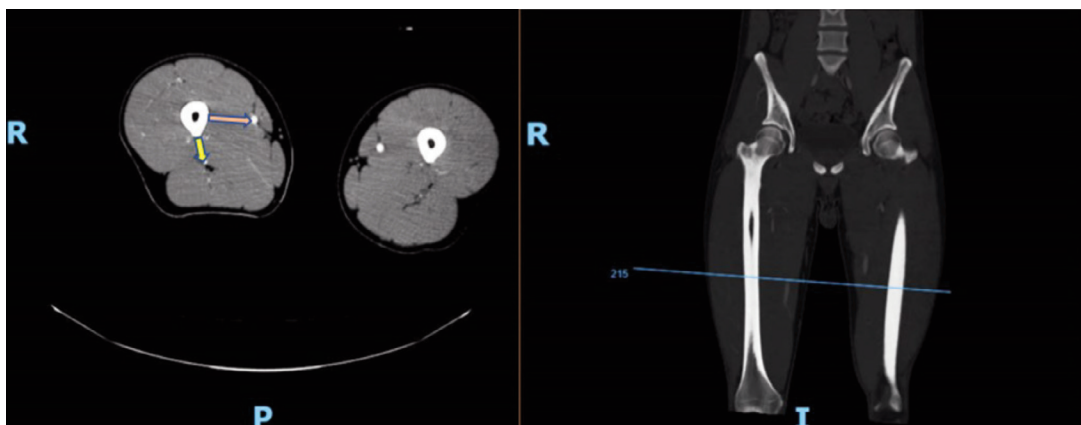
A: Axial and coronal CT (computed tomography) cuts showing how the shortest distance from the outer cortex of the femur at the midshaft of the femur to the superficial femoral and profunda femoris artery is measured (yellow arrow: distance from femur to profunda femoris artery, red arrow: distance from femur to superficial femoral artery).
